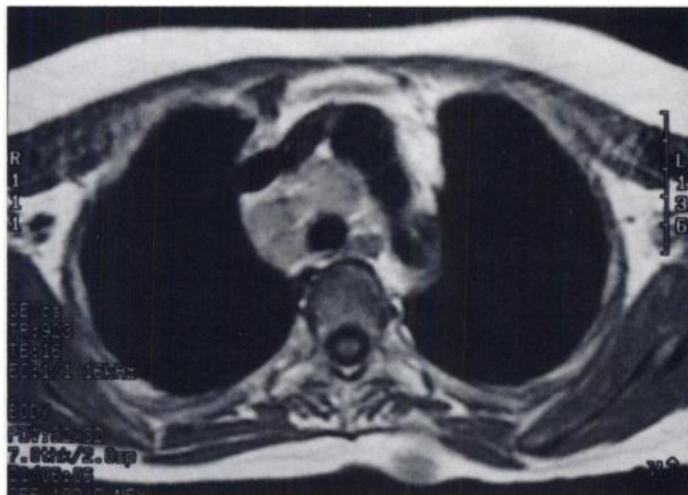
MRI revealed enlarged paratracheal lymph nodes located anterior to the thoracic spine.
